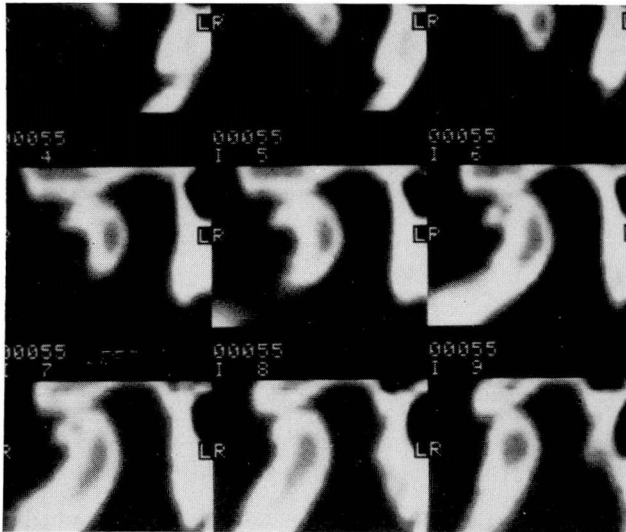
Sagittal, reconstructed computed tomographic images demonstrating a degenerative spur on the anterior aspect of the mandibular condyle. (Images courtesy of Clyde Helms, M.D., UCSF)
